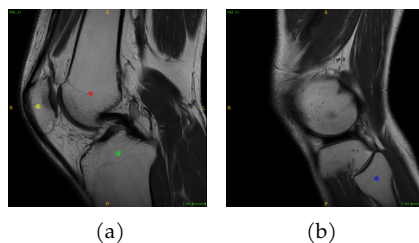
Marking of the seeds of the femur, tibia and patella in plane 17 and fibula in plane 4 of MRI RM_31
